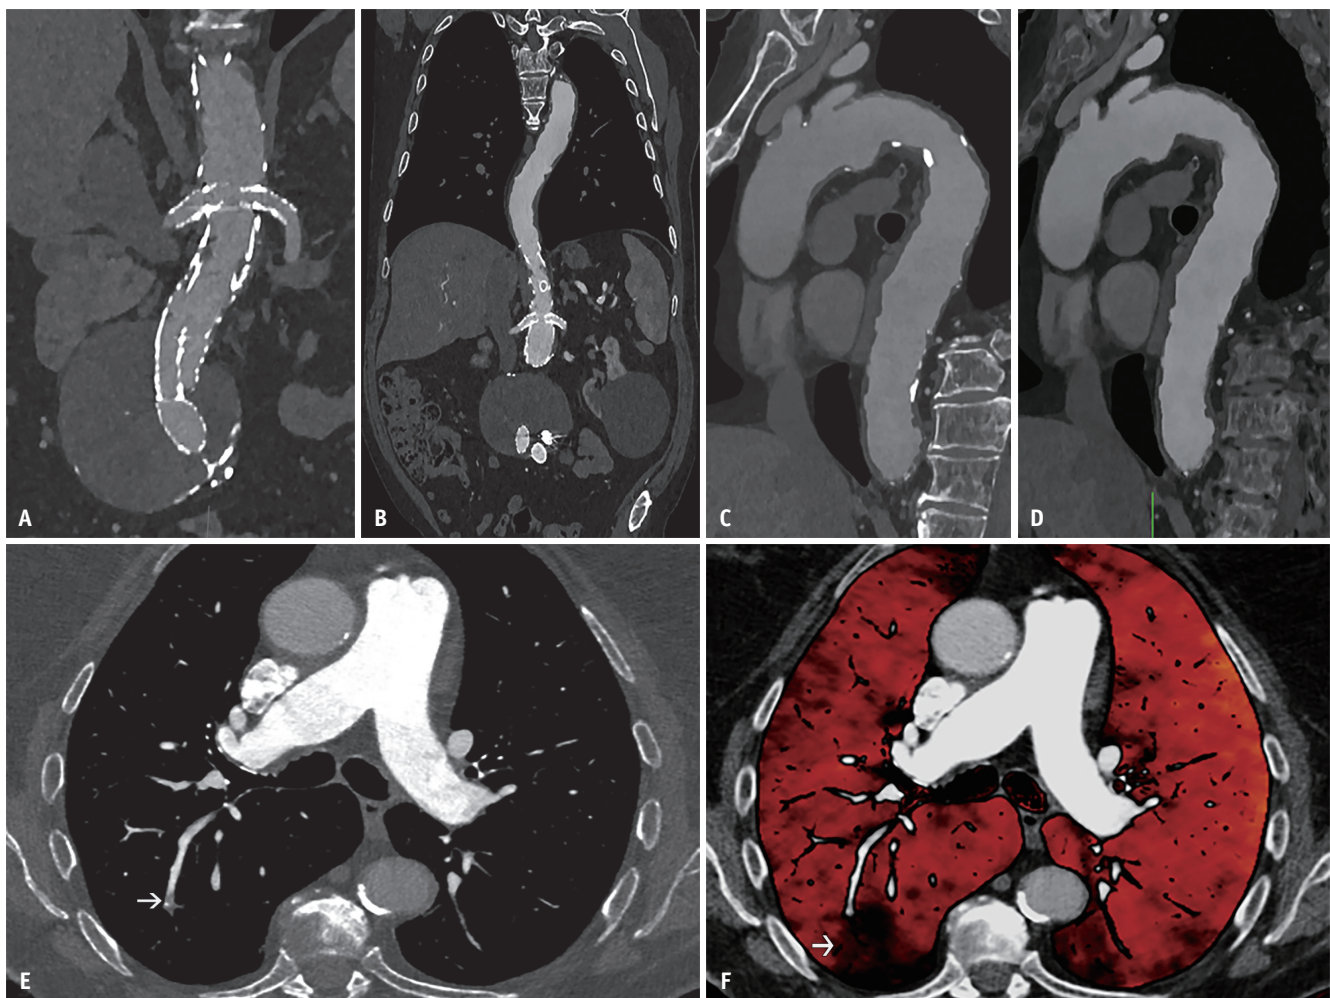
Combined PCCT modes. A: Coronal oblique CTA from PCCT in UHR-ME mode in an 81-year-old male post-fenestrated endovascular aortic repair shows sharp definition of the stent structure, including renal artery stents. B: ME reconstruction in the same patient (50 keV) shows enhanced contrast visualization. C: Sagittal oblique UHR image shows calcified descending thoracic aortic plaque. D: PureLumen reconstruction shows calcium separation with reduced blooming. E: Axial CTA from PCCT in Flash-ME mode in 43-year-old male shows motion-free pulmonary arteries with embolus in the posterior segmental right lower lobe branch (arrow). F: Iodine map in the same patient shows a corresponding perfusion defect (arrow). Flash-ME mode enables simultaneous motion-free imaging of the coronary, aortic, and pulmonary arteries, along with ME maps (iodine, virtual monoenergetic image). PCCT = photon-counting CT, CTA = CT angiography, UHR = ultra-high-resolution, ME = multienergy
